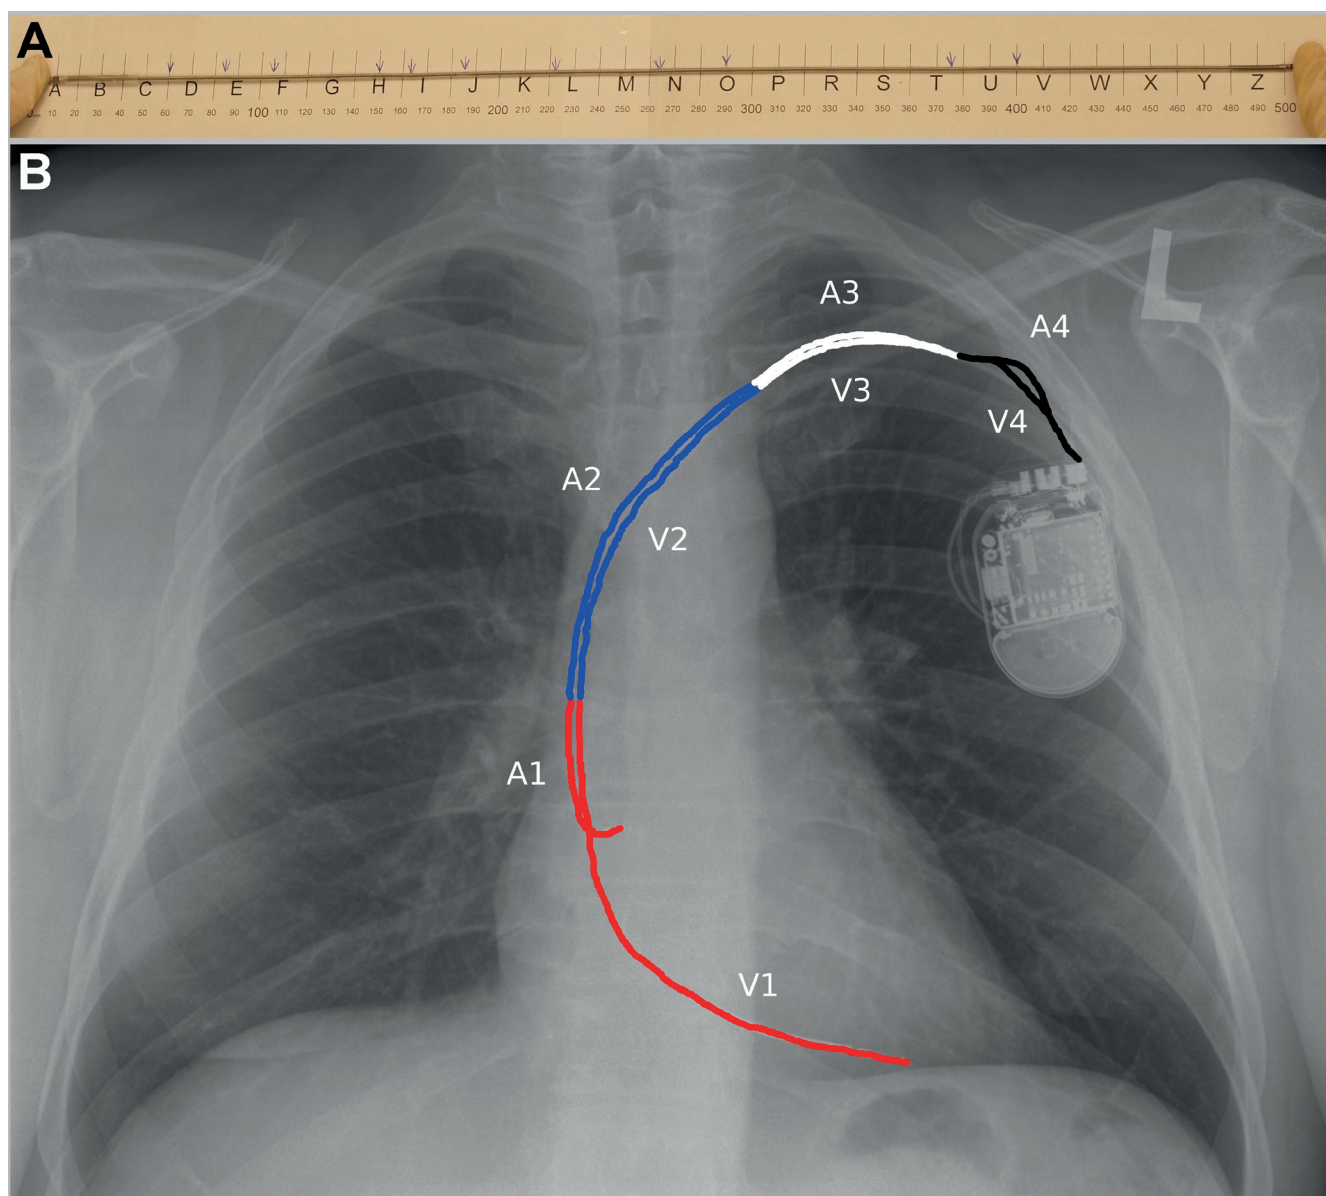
Measuring the location of the lesion. A. The analyzed leads were divided into 2-cm sections. The small arrows at the top of the ruler indicate the locations of destruction; B. Chest X-ray – posteroanterior projection; A – atrial lead; V – ventricular lead; 1 – the intracardiac region, 2 – the intravenous region, 3 – the subclavian region, 4 – the intra-pocket region; the section length measurement was made using the Digital Imaging and Communications in Medicine (DICOM) system; the invisible part of the electrode belongs to the intra-pocket region
